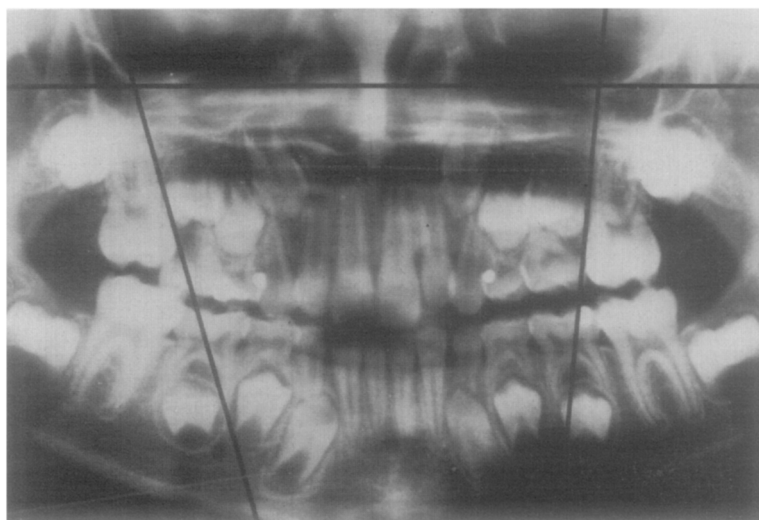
Reference lines used for measurements on the orthopantomogram of the mesial angle of the maxillary first permanent molars.
